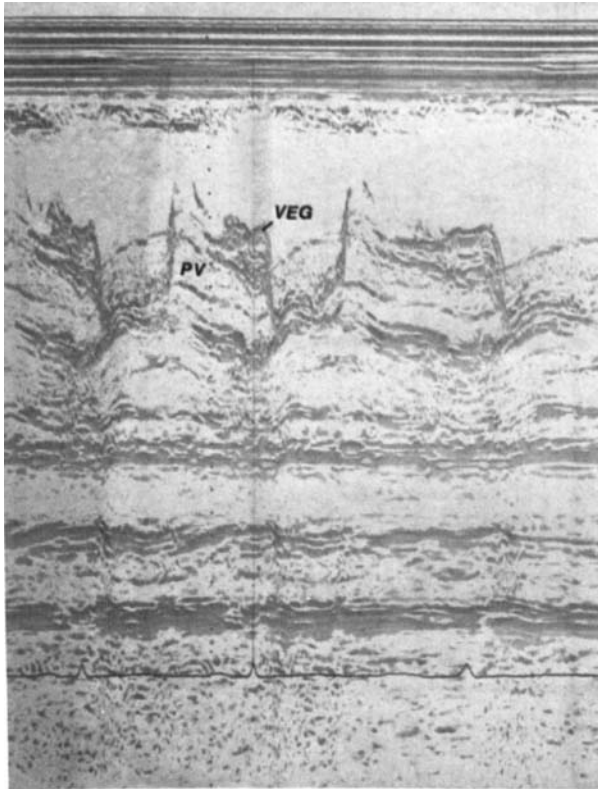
M-mode echocardiogram of the parasternal view showing marked thickening of the pulmonic valve leaflet with normal valve motion. PV: pulmonic valve. VEG: vegetation.
